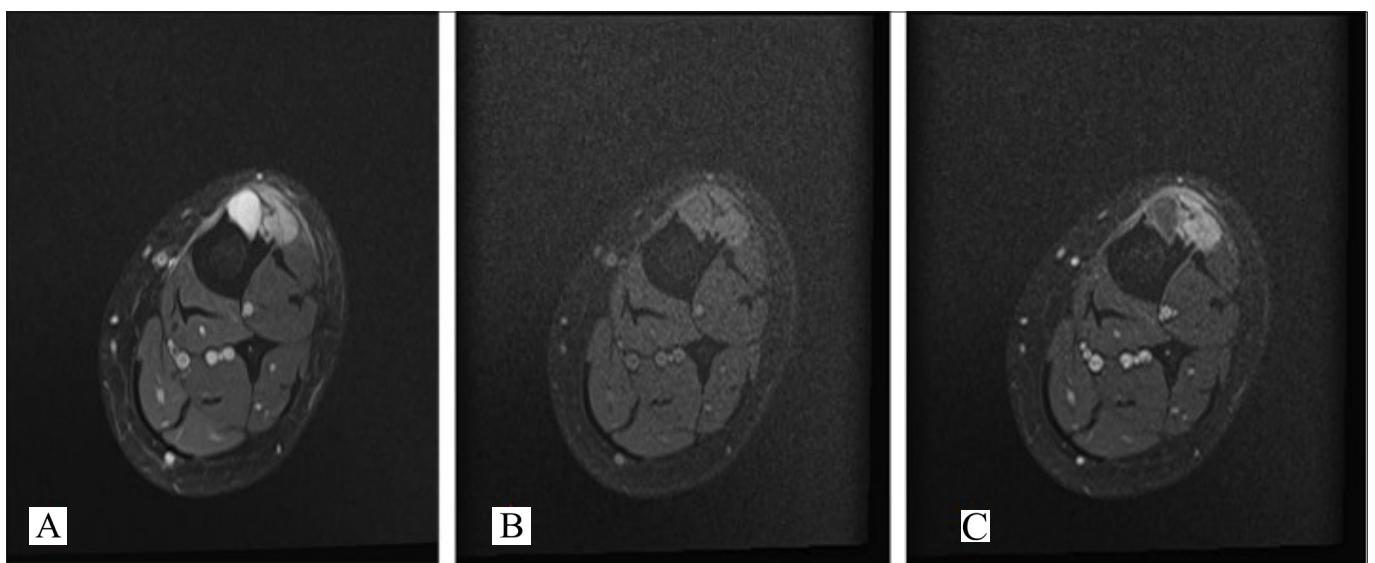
(a) Axial proton density imaging shows a lesion with a cystic component. (b) On axial T1-weighted fat saturated section, an intermediate signal intensity lesion with soft tissue extension destructing the anterior bone cortex was seen. (c) On axial T1-weighted images with fat-selective presaturation after contrast medium administration, lesions show intense enhancement and are well demarcated. The cystic compartment does not show enhancement.
